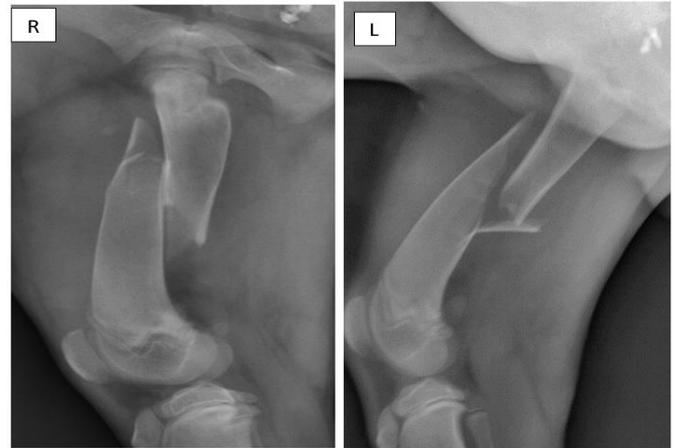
Preoperative radiograph showing oblique overriding femur fracture of both the hindlimbs.
